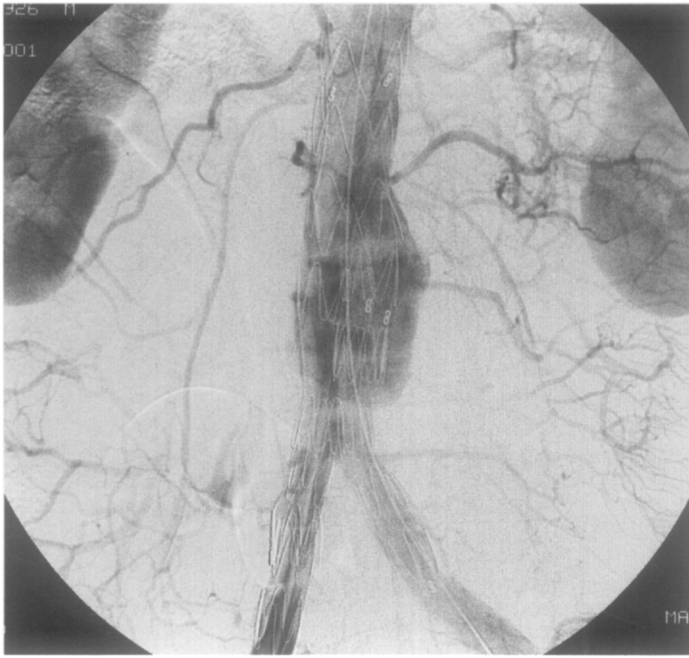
Type IV endoleak. Anteroposterior aortogram immediately after stent-graft implantation shows an endoleak. Contrast was noted to slowly fill the aneurysm sac during the angiogram. It did not appear to originate from the attachment sites or the modular component junctions. This endoleak subsequently resolved on a CT scan performed several days later.
